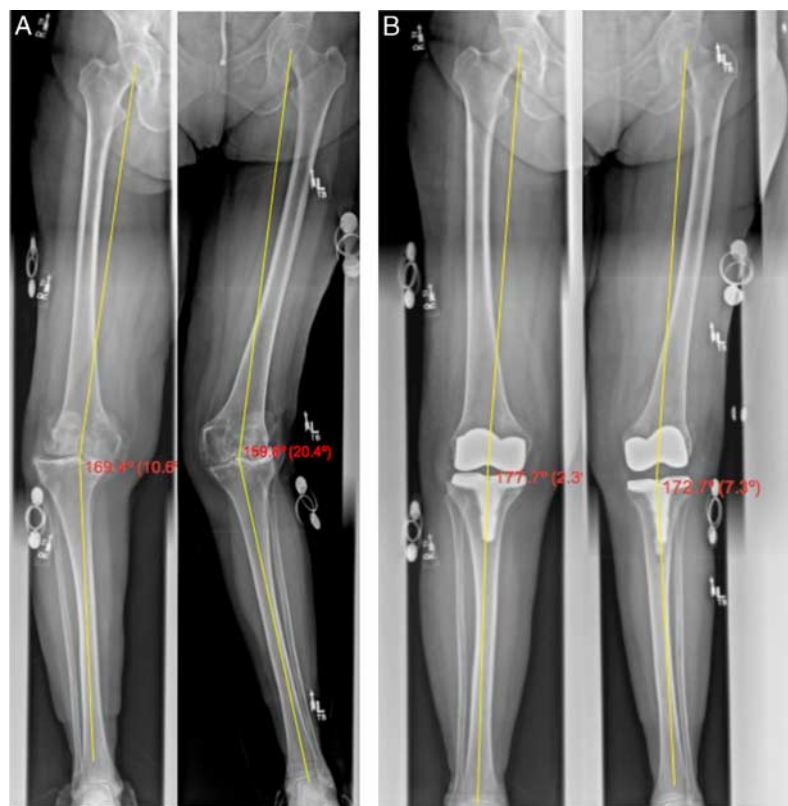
A, Severe valgus (20.4 degrees left knee) and varus (10.6 degrees right knee) malaligned knees, a so-called “wind-swept” deformity preoperatively. B, Postoperative radiographs of (A) showing improved coronal alignment (20.4 to 7.3 degrees valgus left knee and 10.6 to 2.3 degrees varus right knee) and patient-reported outcomes revealed “back to normal” (level of improvement: 4) and “completely satisfied” (patient satisfaction: 6).
